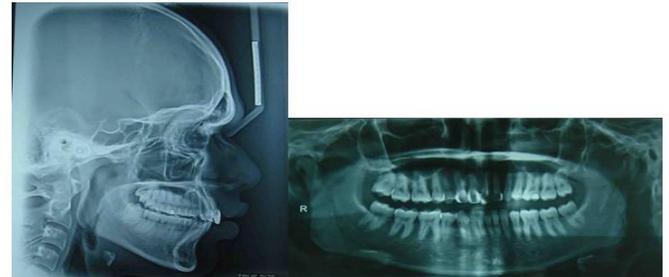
D: Post Treatment Radiographs
